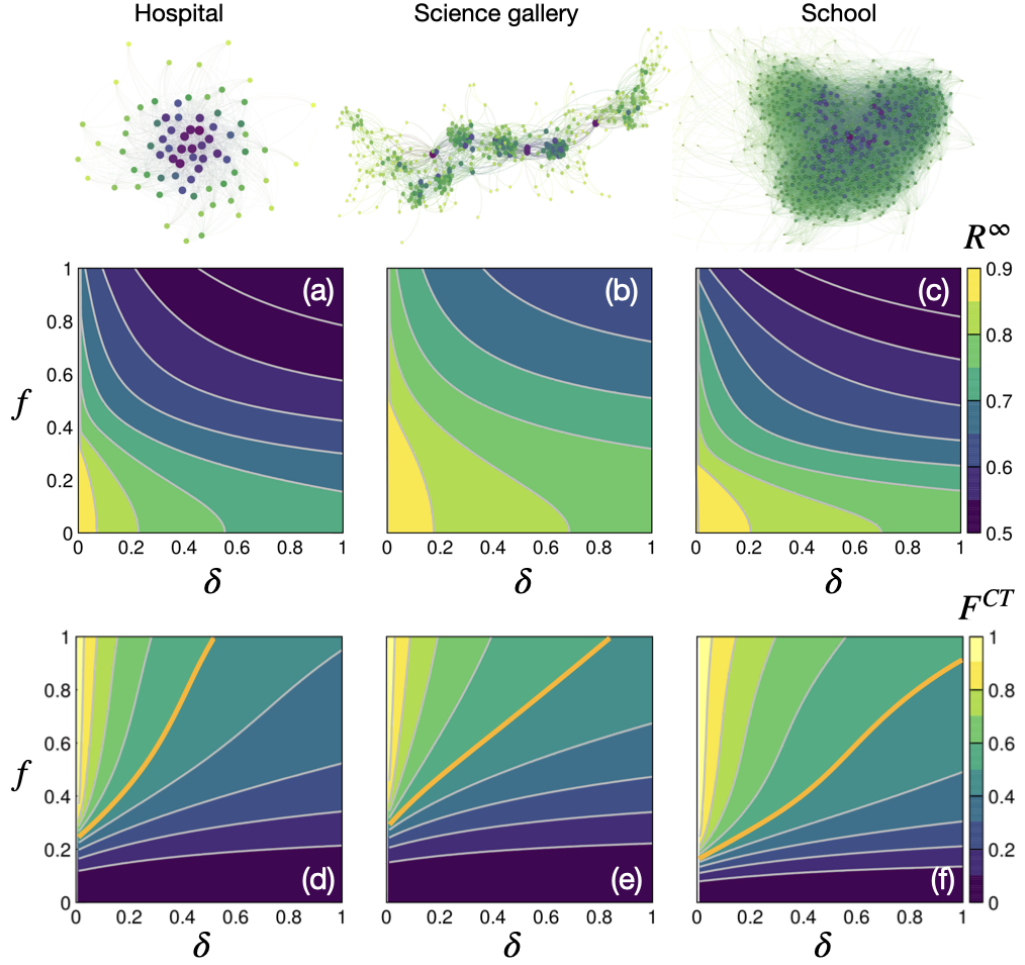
CT vs symptomatic detection in three proximity networks. The color and size of the nodes is proportional to their connectivity, being the small (large) and yellow (blue) ones those vertices with the smallest (largest) degree. Panels (a)-(c) show the attack rate, R^∞ as a function of the quality of symptomatic δ and CT detection f . Panels (d)-(f) show the fraction of detected cases by CT, F^{CT} . We have highlighted the case $F^{CT} = 0.5$ (orange line) signalling that symptomatic and CT detections identify the same number of cases. The infectivity probability per contact ($\beta_S = \beta_A = \beta$) is chosen so that the attack rate in the absence of any kind of detection ($\delta = f = 0$) is $R^\infty = 0.9$ for the three networks.
